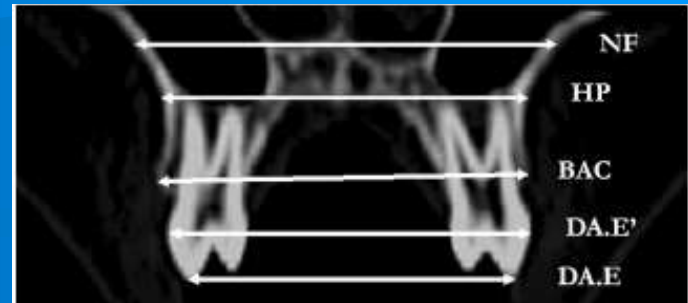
External maxillary widths. NF indicates maxillary width parallel to the lower border of the CT image and tangent to the nasal floor at its most superior level; HP, maxillary width parallel to the lower border of the CT image and tangent to the hard palate; BAC, maxillary width at the level of the buccal alveolar crest; DA.E', dental arch external width measured at the most prominent area of the buccal aspect of the posterior teeth; and DA.E, dental arch external width measured at the level of the buccal cusp tips.
